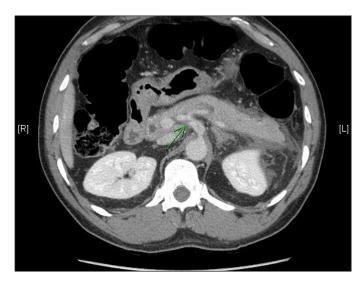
CT abdomen/pelvis showing dissection extending to the trifurcation of celiac trunk.
